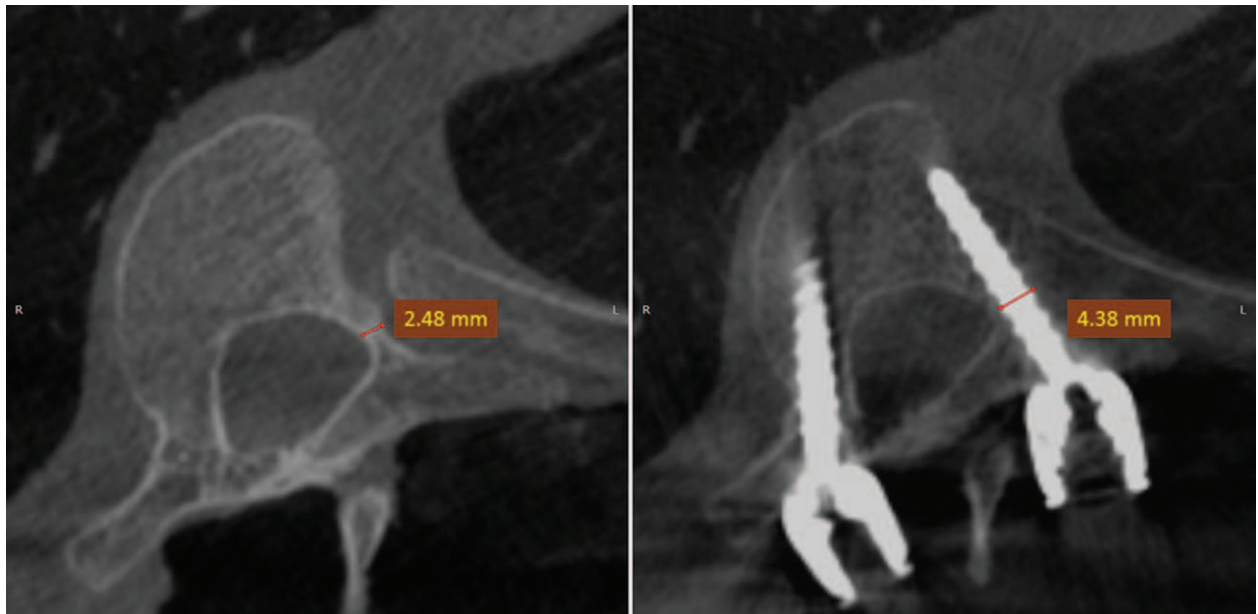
Planning 3D-Cone Beam CT showing pedicle isthmus measurement of 2.5 mm at T7 left in the concave side and at the apical region of a scoliotic patient (left sub-figure). Corresponding verification 3D-CBCT scan with a 4.35 mm 80% larger than the pedicle (pedicle-to-screw size) which was rated as a grade 2 screw.
